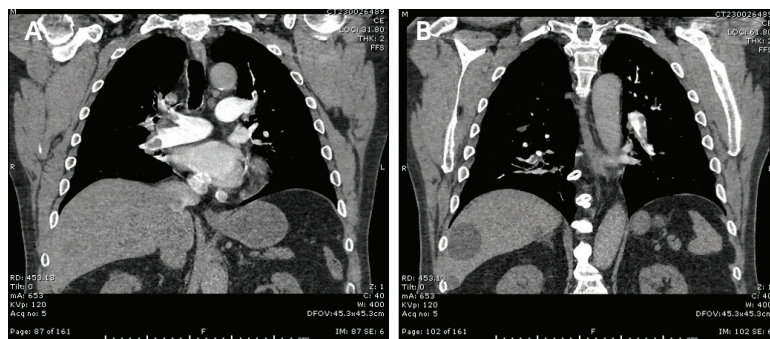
CT of the chest showing thrombus burden in the interlobal and TA branches (A) and thrombus burden in the left PA (B).
